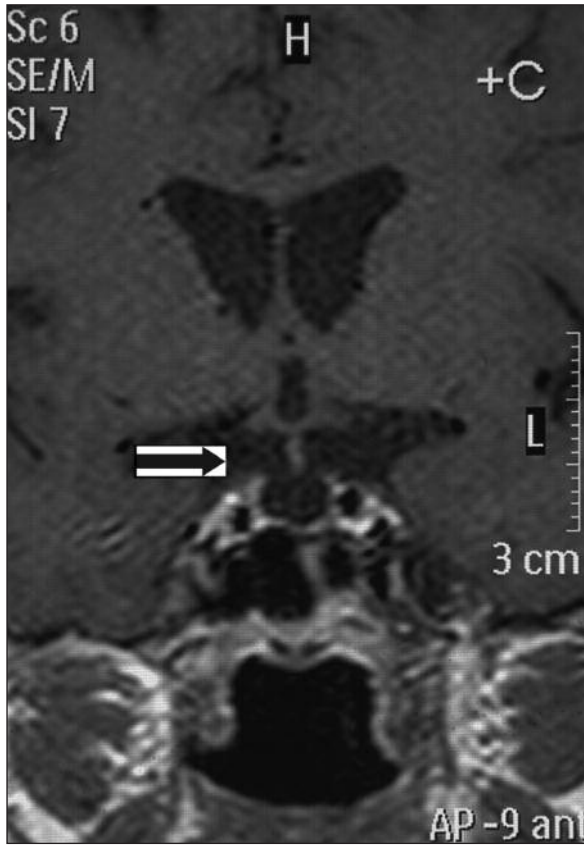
MRI of hypophysis showing enlarged sella with lack of a soft tissue and without any tumor in it.
